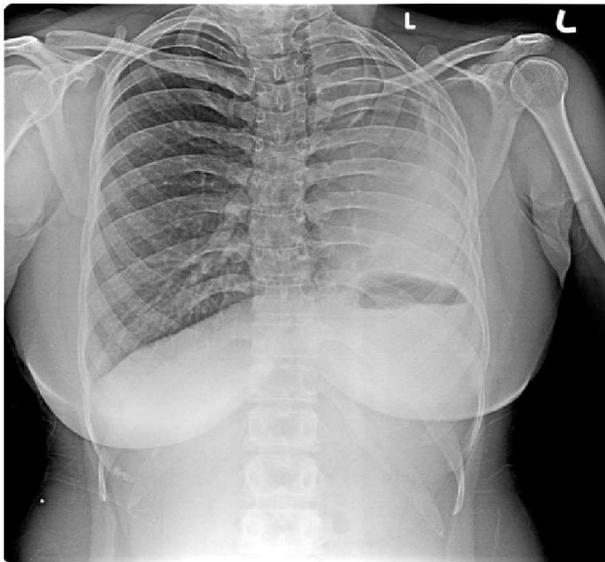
Chest X-Ray showing homogenous opacity with loss of lung volume in the left hemithorax
